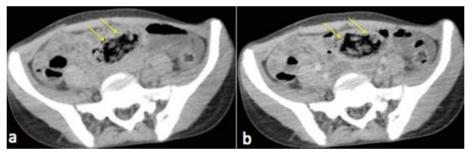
Axial Computed Tomography: (a) without intravenous contrast, (b) Contrast-enhanced CT scans: Small bowel intraluminal mass heterogeneous non-enhancing and contained air (yellow arrow)
